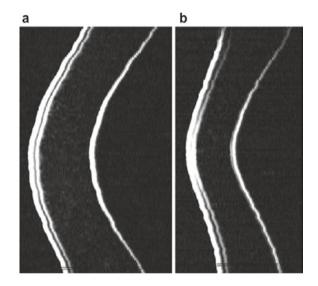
a (left) B-scan of a normal cornea using the Artemis very high-frequency digital ultrasound arc scanner. The epithelium appears uniform in thickness across the 10 mm diameter of the scan. b (right) B-scan of a keratoconic cornea using the Artemis very high-frequency digital ultrasound arc-scanner. The epithelium appears very thin centrally coincident with a visible cone on the back surface. The epithelium is clearly thicker either side of the cone. The central epithelium is much thinner and the peripheral epithelium is much thicker compared to normal eye. Reuse from Springer [2]
